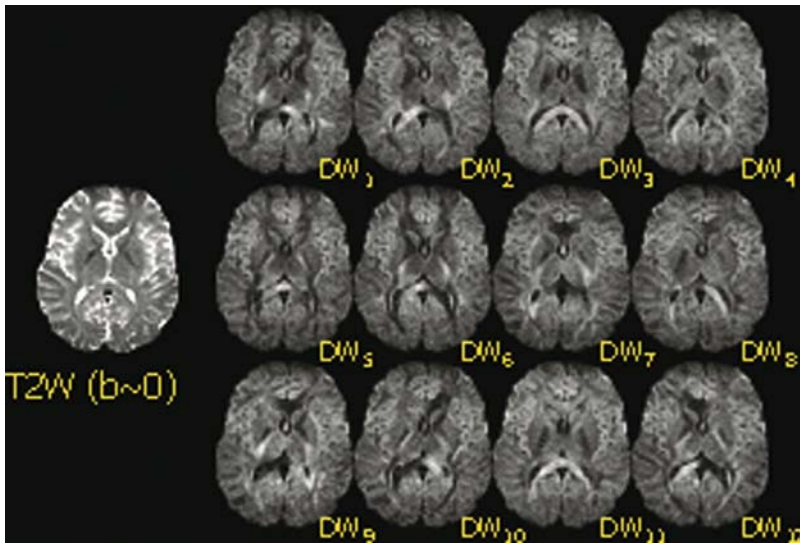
Example images from a DTI study for a single slice in a human brain. The image on the left is without any diffusion-weighting and is T2-weighted. The twelve images on the right were obtained with diffusion weighting ($b = 1000 \text{ s/mm}^2$) applied in twelve non-collinear directions. Note that the image contrast changes significantly with the diffusion encoding direction
